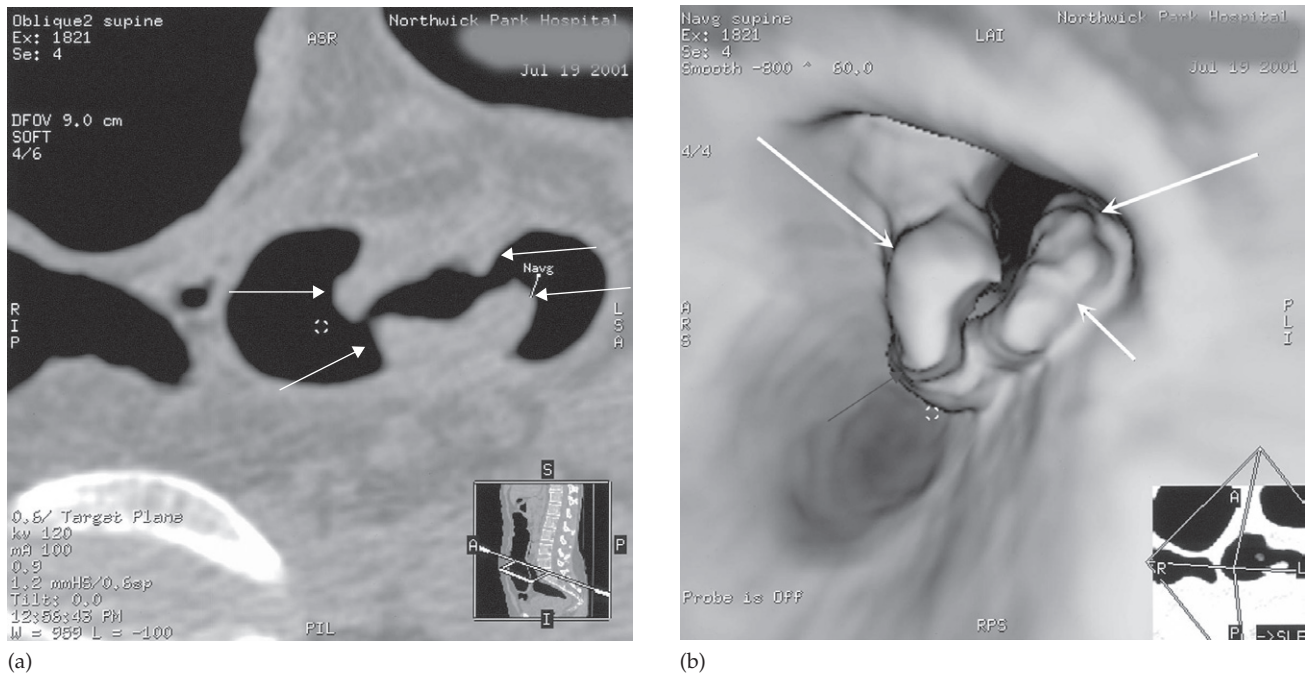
Colon carcinoma shown by CT pneumocolon. (a) Oblique axial section showing a stricture with classic shouldered edges (arrows). (b) Virtual colonoscopy demonstrating the irregularly shaped tumour (arrows).
